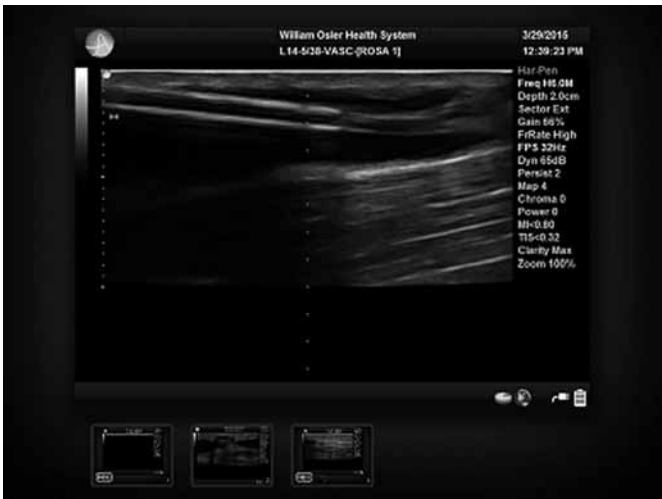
Ultrasound image of the jet flow effect inside the vessel lumen. The flow directed to the center of the vessel lumen shows as two white parallel bands beyond the tip of the plastic cannula.
